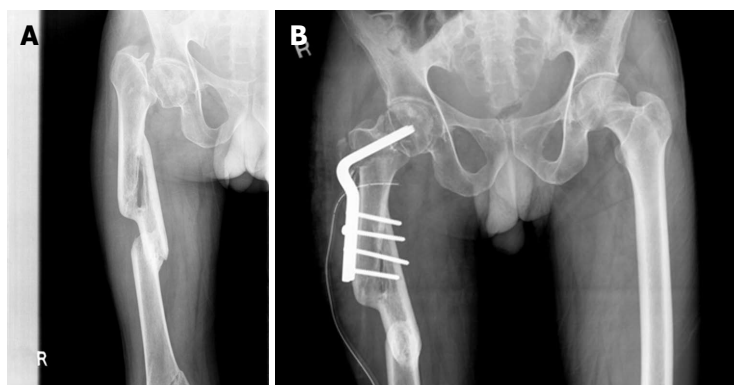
Problems with neglected fractures. A: Anteroposterior radiograph of pelvis of a 41-year-old male with a 3-mo-old nonunion neck of femur fracture and associated malunioned femur fracture; B: At 4-year follow-up showing union, when the Harris hip score was 88.
